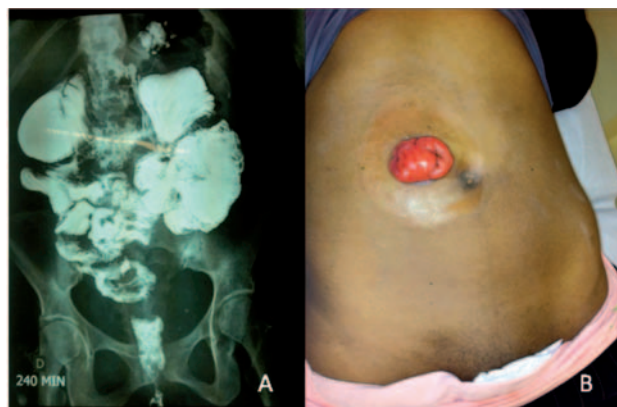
A: contrast radiography demonstrating enterovaginal fistula; B: colostomy.
